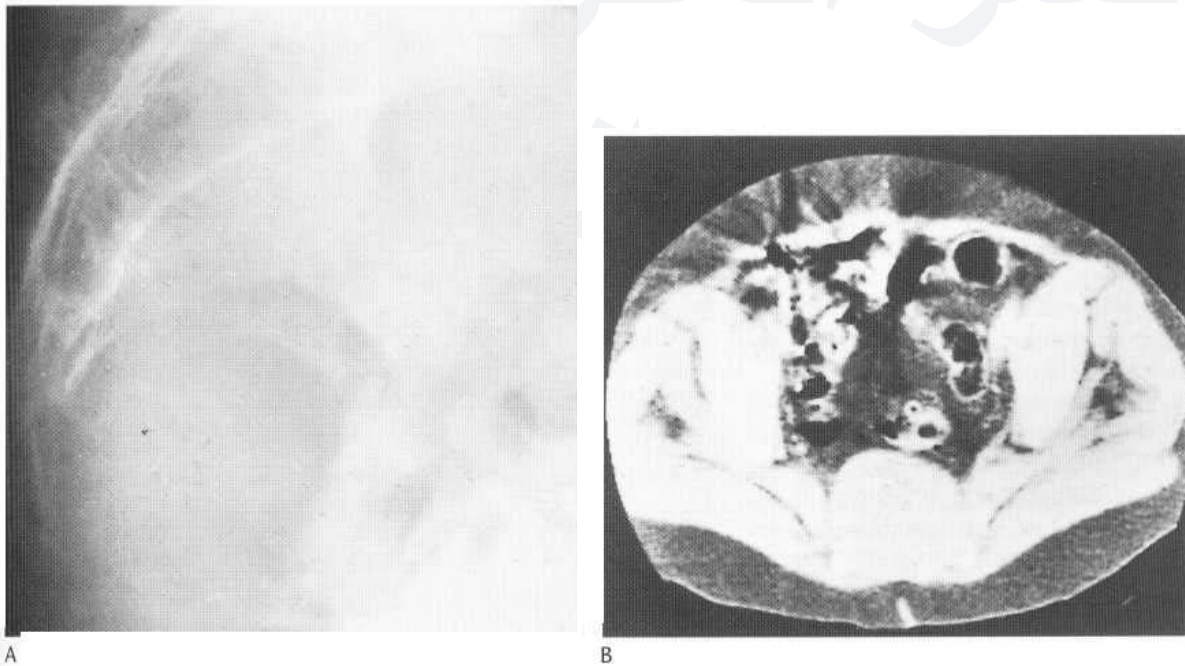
Chordoma of the distal sacrum. (A) A lateral film demonstrates a large soft-tissue mass displacing bowel anteriorly. The anterior cortex of the distal sacral vertebrae is ill defined and the coccyx is not seen. (B) CT demonstrates the typical well-defined soft-tissue mass extending anteriorly from the sacrum. The anterior cortex of the sacrum has been destroyed. Chordomas usually exhibit an apparent disproportion between the size of the soft-tissue mass and the extent of the bony involvement.
